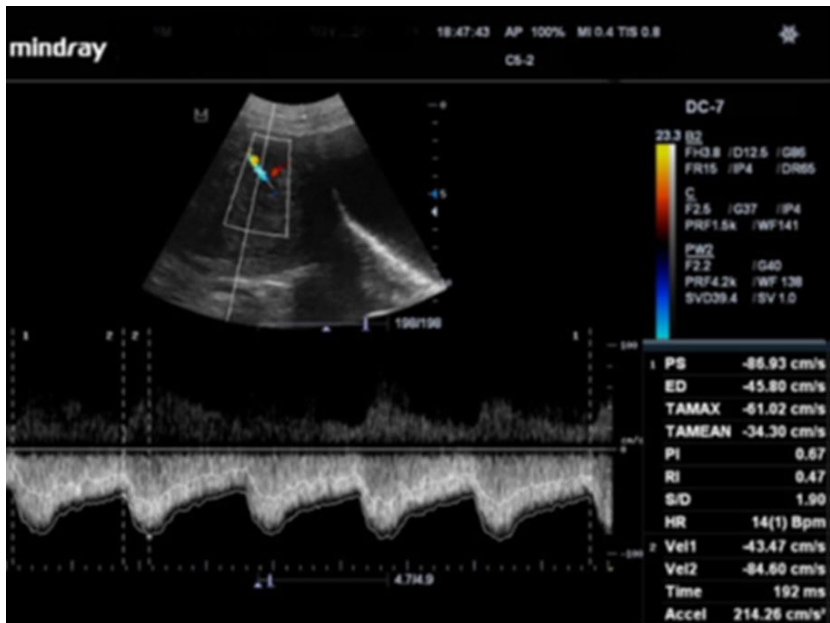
b. Longitudinal triplex sonogram of a myomatous uterus showing the waveform pattern and Doppler indices of an intrafibroid (core) artery. (Idowu BM *et al* 2018)
